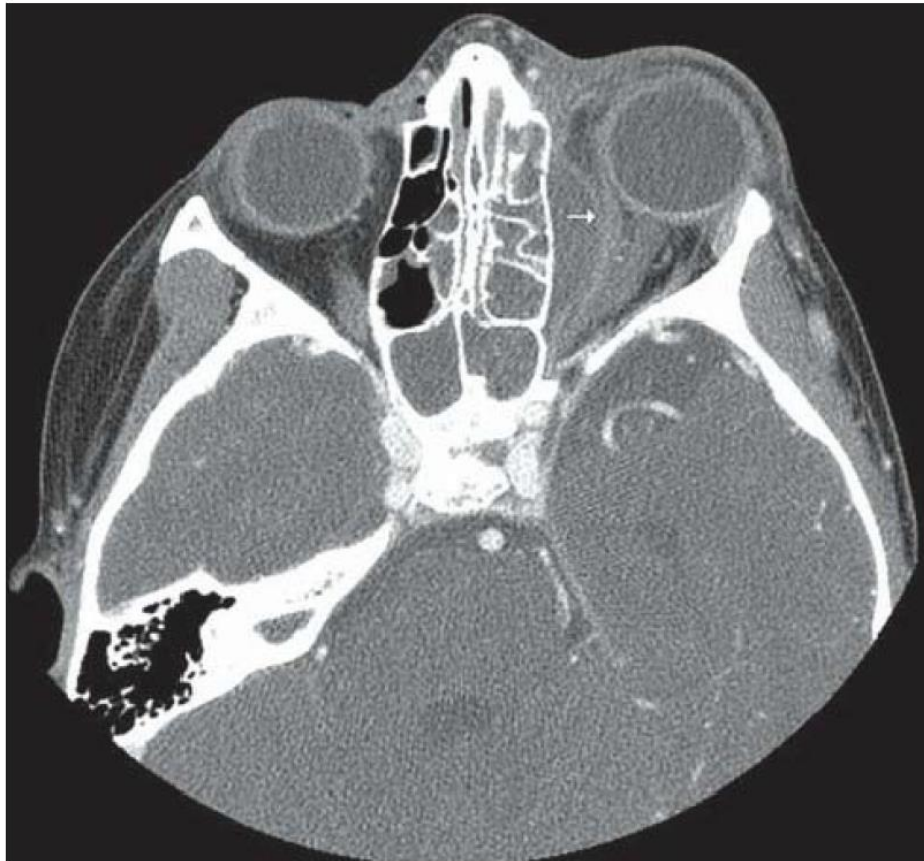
Axial CT scan demonstrating a left subperiosteal orbital abscess. The abscess is immediately adjacent to the lamina papyracea (the *arrow* is inside the abscess and identifies the lateral edge of the abscess); note the proptosis and the displacement of the orbital periosteum and medial rectus muscle.
